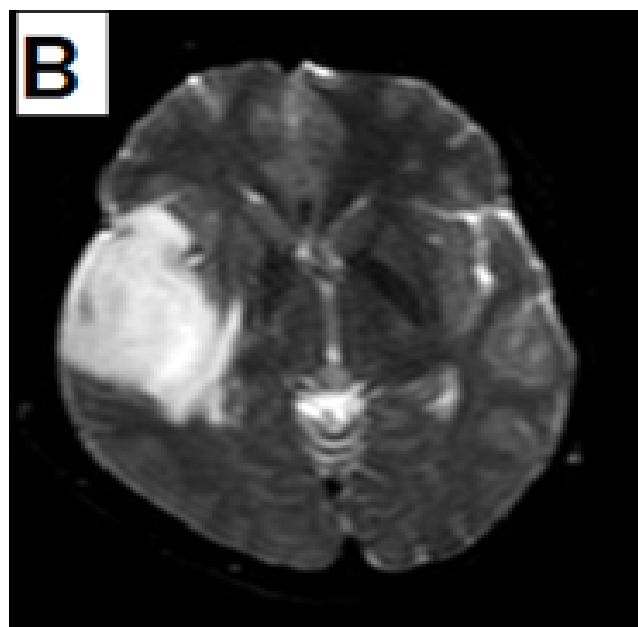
(B). MRI brain revealed a minimally enhancing mass in the right frontotemporal lobes with increased Cho/NAA ratio and involvement of the right MCA branches, suggestive of low-grade glioma
